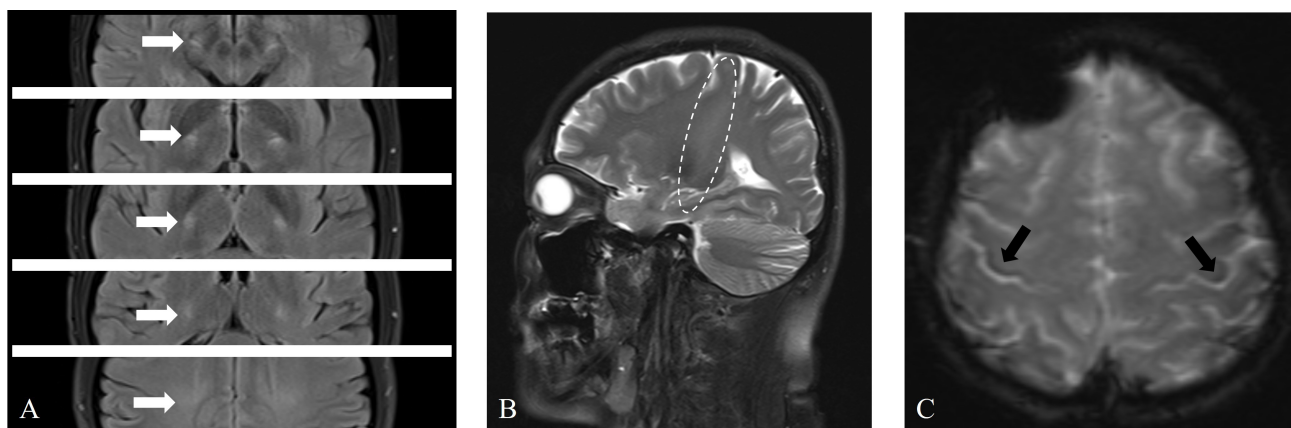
Brain magnetic resonance imaging (MRI) revealed abnormal signals in the bilateral corticospinal tract (CST) and bilateral precentral gyrus. (A) Axial T2 fluid attenuated inversion recovery (FLAIR) sequences showing symmetrical high signals in the CST bilaterally (white arrows). (B) Sagittal T2 sequences revealing long-segment high signals in the CST (elliptical circle). (C) Axial T2-star weighted imaging (T2*) sequences showing asymmetric curvilinear bands of low signals in the precentral gyrus (right more than left) (black arrows).
